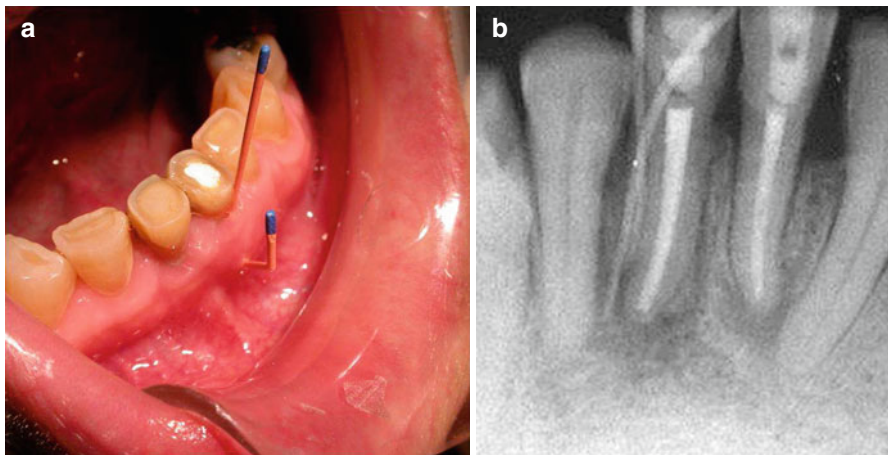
Patient presented to the dental office with a request to restore the two mandibular central incisors. From the patient history, it was revealed that 7 years earlier, two root canal treatments were performed as a result of pulp exposure due to severe bruxism. Clinical examination revealed temporary restoration in the lower left incisor, 8 mm probing defect in the buccal aspect, and a sinus tract in the attached gingivae (a). The periapical radiograph (b) reveals two large areas of radiolucencies around the tip of the two roots and the two tracings of gutta-percha shown in a
